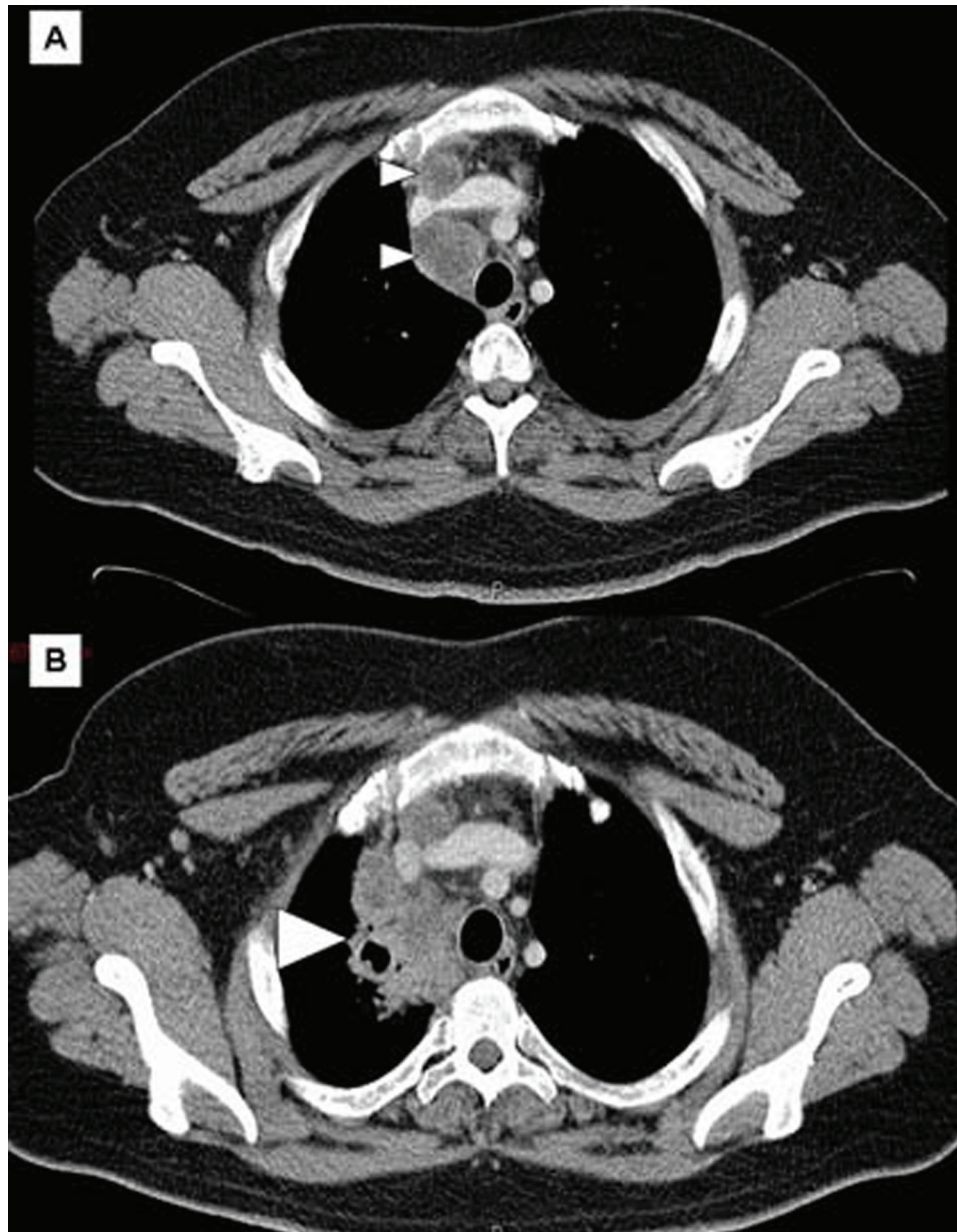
CT scans of chest. (A) At onset of symptoms showing enlarged mediastinal lymph nodes (small arrow heads). (B) After commencing antituberculous therapy and stopping anti-TNF α therapy, showing new consolidation and cavitation (large arrow head).
